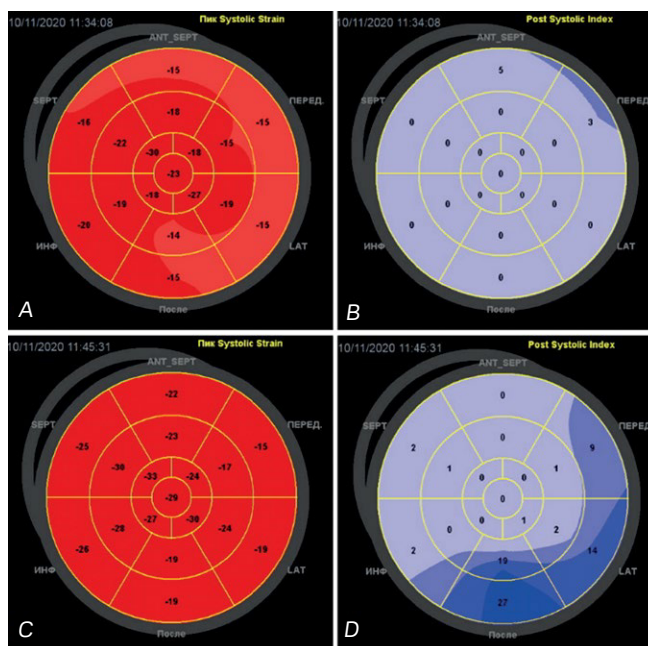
Results of speckle-tracking echocardiography at rest (A, B) and after dosed physical exercise (C, D) in a patient with 95% stenosis of the circumflex branch of the left coronary artery.
